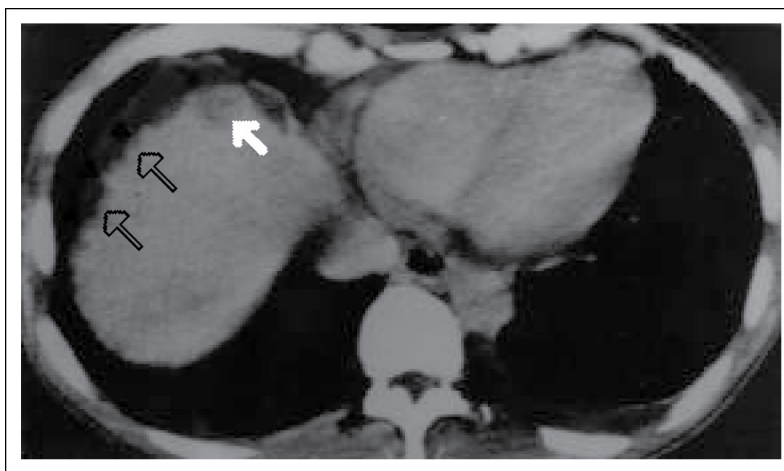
Caption for the CT images: CT liver: Hypodense nodules in the right lobe (arrowed). The liver outline is irregular (arrowheads)*
